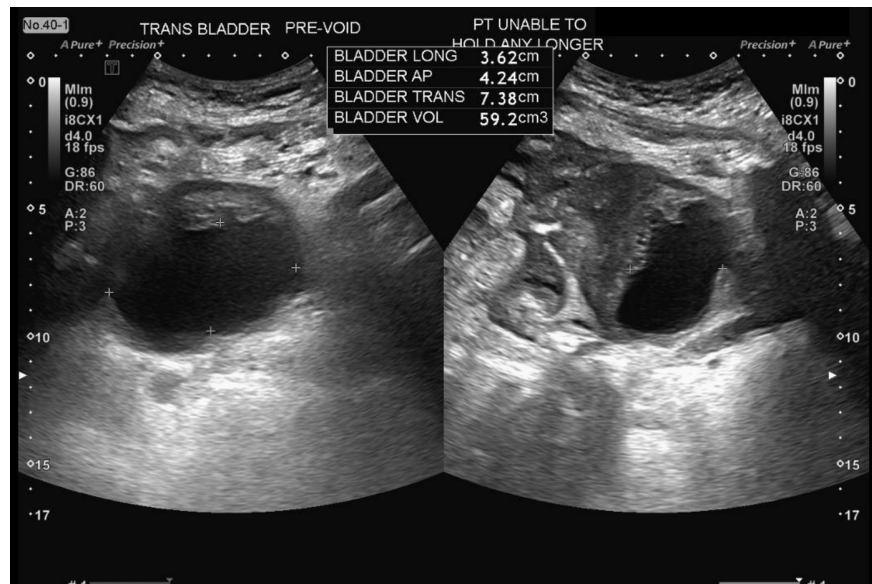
The unread clue. Bladder ultrasound: irregular mass-like wall thickening of the dome, acquired roughly 18 days before the CT but unread for a month.
